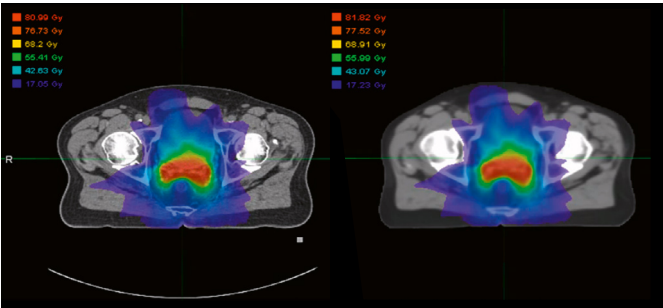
Exemplary dose distributions of a treatment plan calculated on the planning CT (left) and the MR-based Synthetic CT (right).
